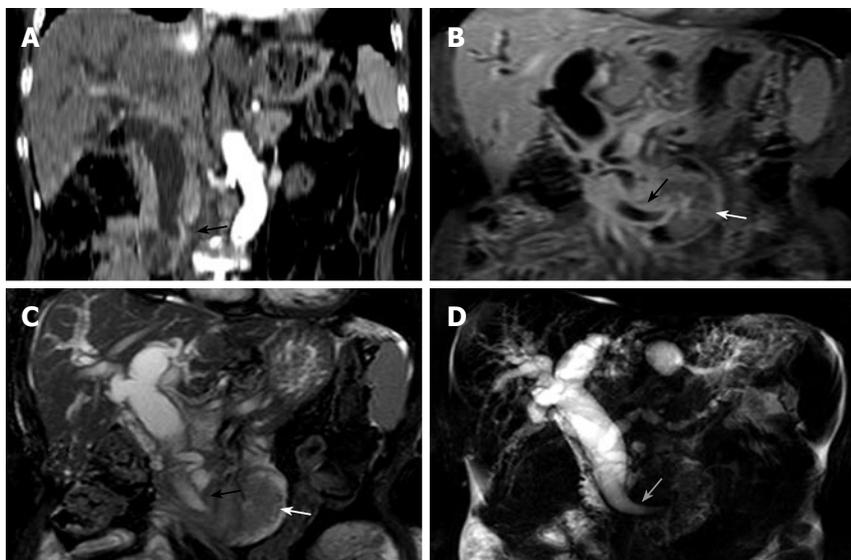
Dilated pancreatic and biliary ducts with ectopic drainage. A: Coronal MDCT image of CT reveals a low termination of the common bile duct (arrow); B and C: Coronal MR images show ectopic pancreaticobiliary junction, low termination of the common bile duct (black arrows), and the mass (white arrows) located on the proximal jejunum; D: MRCP shows dilated pancreatic and biliary ducts. (These photographs were processed by Adobe Photoshop Creative Suite 2.).
